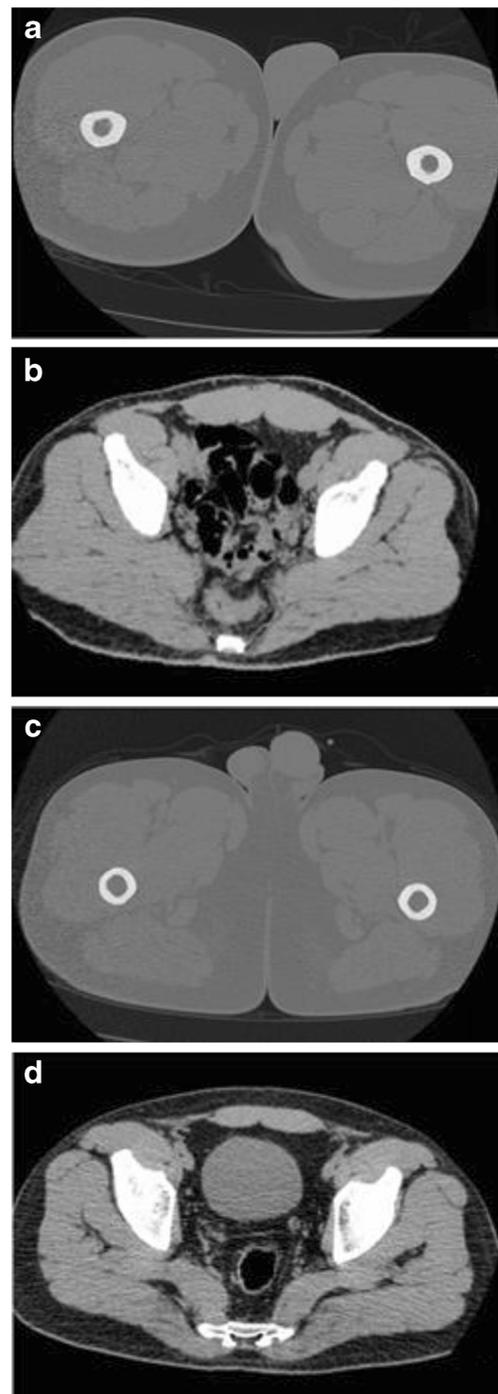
Examples of pre- and post-optimization examinations with relevant patient and dose data. a, b Pre-optimization pelvis CT in a 35-year-old with BMI of 29 kg/m², CT dose index (CTDI)vol 35.9 mGy, dose-length product (DLP) 1,194.1 mGy-cm. Reader 1 quality score = 3, Reader 2 quality score = 3. c, d Post-optimization pelvis CT in a 32-year-old with BMI of 27 kg/m², CTDIvol 10.3 mGy, DLP 291.5 mGy-cm. Reader 1 quality score = 3, Reader 2 quality score = 2
